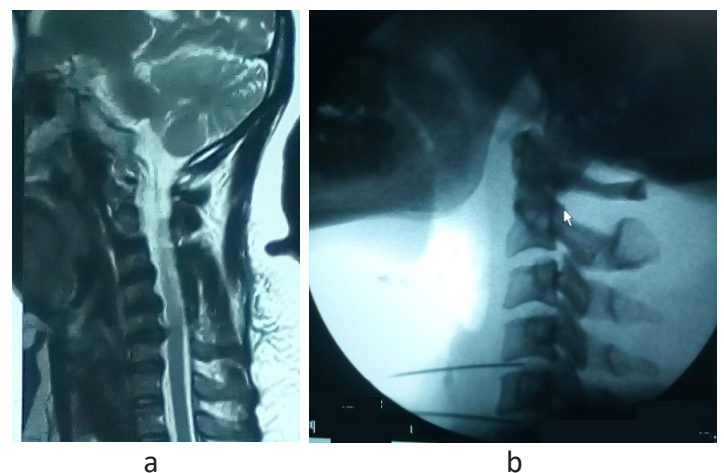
Images of a case of ozone discolysis. (a) Pre-procedural MRI T2-weighted sequence and sagittal section showing a C5C6 disc herniation and C4C5 disc protrusion. (b) Per procedural fluoroscopy showing the discolysis needle implanted in C4C5 and C5C6.
